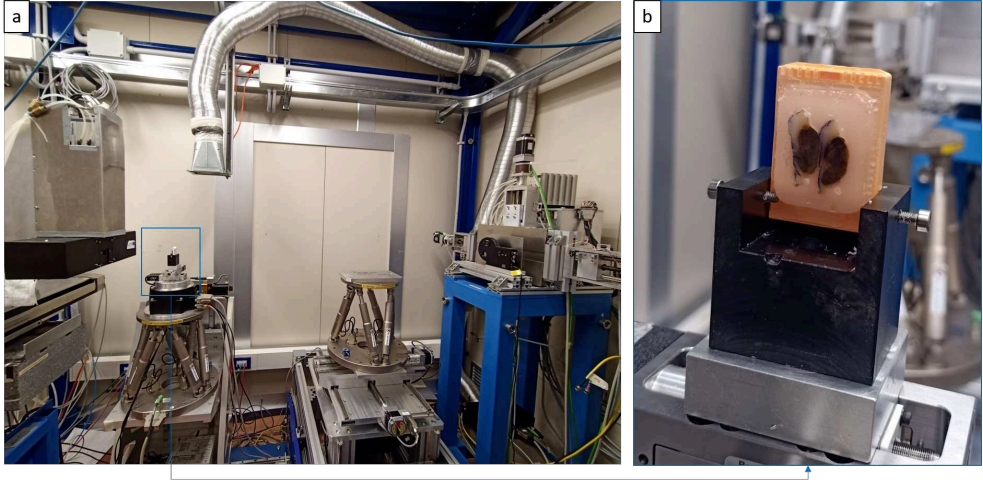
(a) Image of the setup taken at the SYRMEP beamline of Elettra synchrotron (Trieste, Italy) in 2022. From the right to the left, X-rays coming from the accelerator pass through the sample positioned onto the rotator stage and then are collected by the detector coupled with a scintillator. (b) A dedicated sample stage employed for XVH applications.
